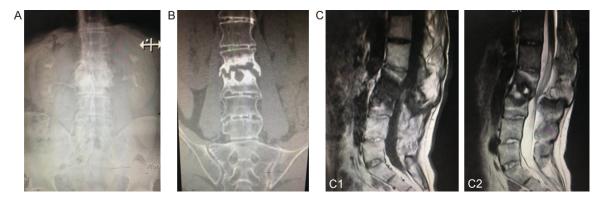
A. Full spine X-ray; B. Lumbar CT plain film; C. Plain MR scans of the lumbar spine (C1. T1-weighted; C2. T2-weighted).
